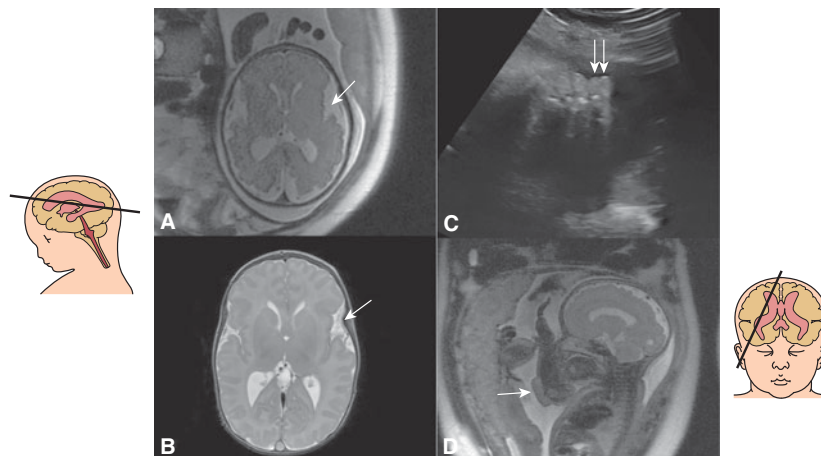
Macrocephaly/vascular malformations syndrome. Prenatal at 32 weeks of gestation (A) and postnatal at 2 months of age (B) axial T2-weighted MRI show an abnormally open operculum lined with an abnormal cortex (polymicrogyria) (arrows). (C) Ultrasound (US) at 33 postmenstrual weeks shows syndactyly of foot fingers 5 and 6 (arrows). (D) Fetal MRI shows a hemangioma of the elbow (arrow).
